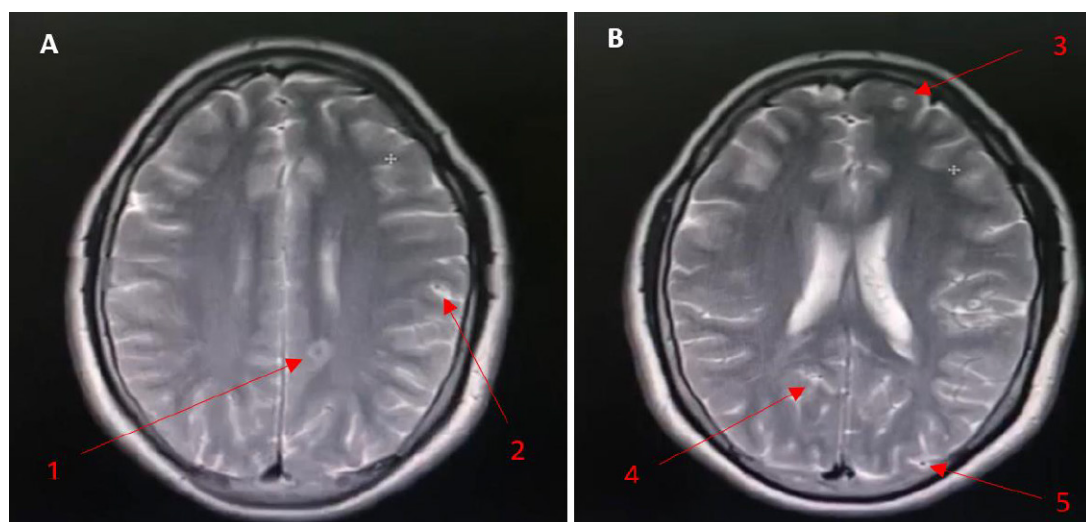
T2-weighted MRI, multiple cystic lesions with eccentrically target lesion mainly seen at grey-white matter junction (A1, B4) and subarachnoid space (A2, B3, B5) of cerebral hemispheres. There is associated perilesional oedema
